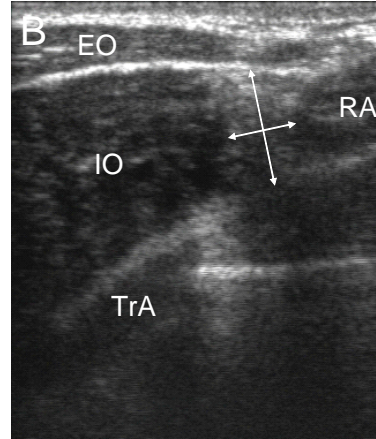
Ultrasound image, taken transverse through the abdomen, of the IO aponeurosis (indicated by arrows) at relaxation.
